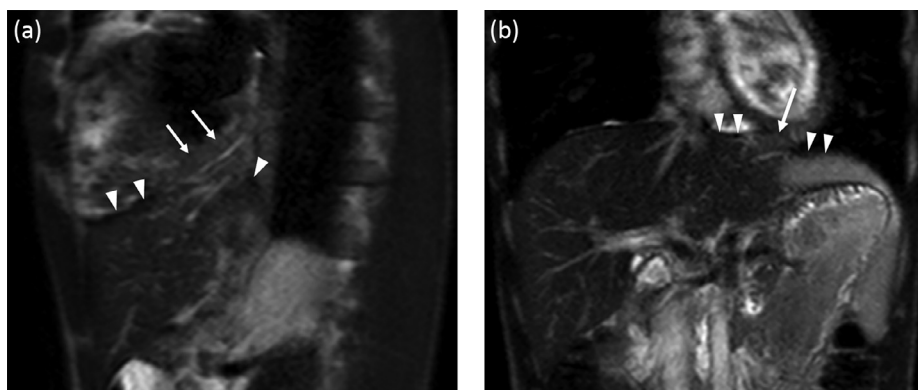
Unenhanced MRI. Sagittal (A) and coronal T2-weighted TSE with fat saturation (B) accurately show the diaphragmatic outline (arrowheads) focally interrupted with small herniation of the second hepatic segment (arrow).
